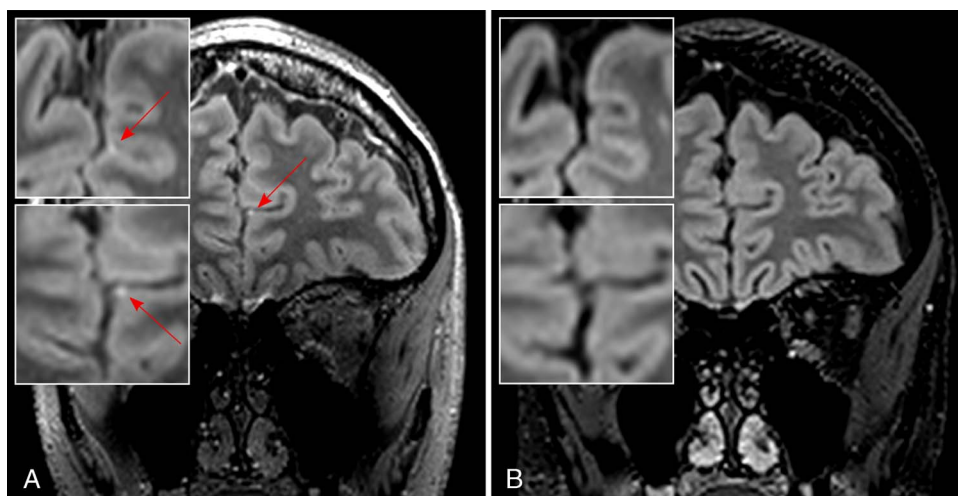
Leptomeningeal enhancement in MS. Ultra-high-field imaging at 7 T is able to sensitively detect foci of leptomeningeal enhancement (LME, red arrow) as demonstrated in this postgadolinium T2-weighted fluid-attenuated inversion recovery (T2-FLAIR; spatial resolution, 0.7 mm isotropic) sequence from a progressive MS patient with interhemispheric LME (A, with magnified axial [top] and coronal [bottom] images), which is not detected on postgadolinium T2-FLAIR images at 3 T (B, with magnified axial [top] and coronal [bottom] images). Both T2-FLAIR images were acquired ≈10 minutes after contrast medium administration.
